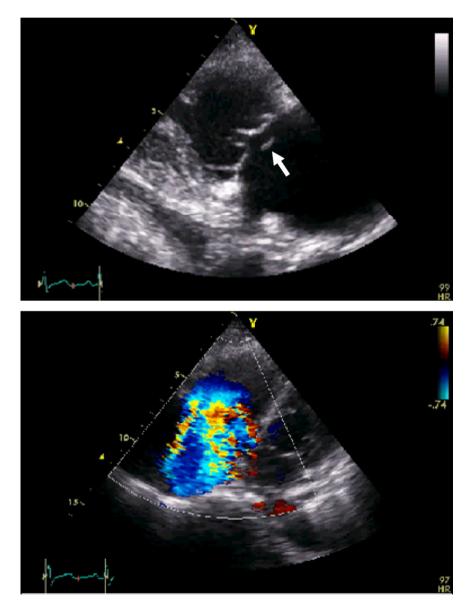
Two-dimensional echocardiogram (Day 5) revealing vegetation (white arrow:  $3 \text{ mm} \times 7 \text{ mm}$ ) on the tricuspid valve and moderate tricuspid valve regurgitation.
